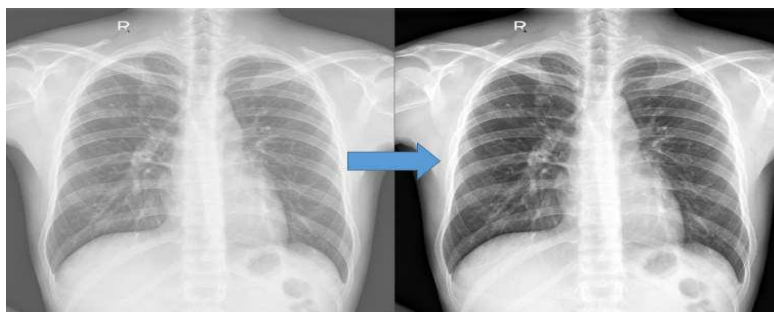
X-ray Contrast Enhancement
